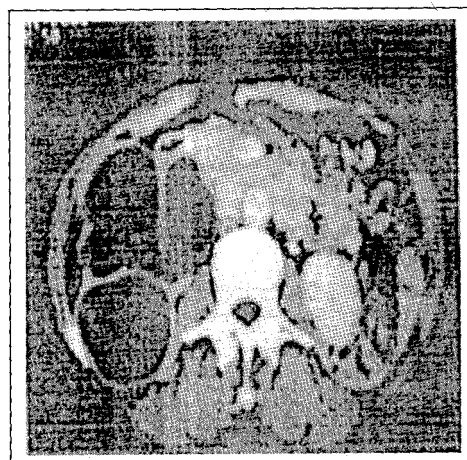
CT scan of the abdomen showing a multiseptated right kidney and a normal left kidney
